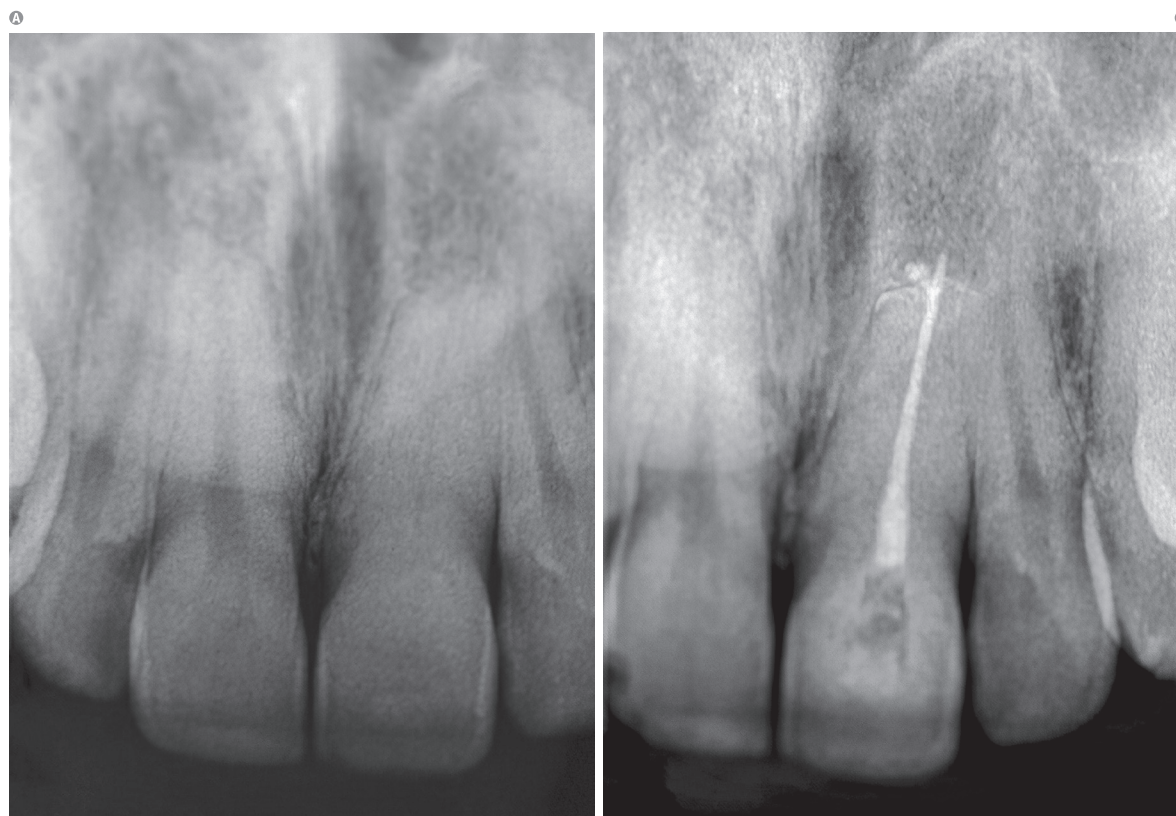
A) Radiograph of the traumatized tooth before the root canal treatment was performed; B) Radiograph of the tooth after the root canal treatment.
